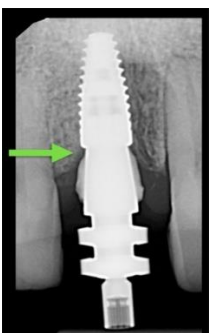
Radiograph showing open tray impression coping attached to the implant fixture (arrow depicts
